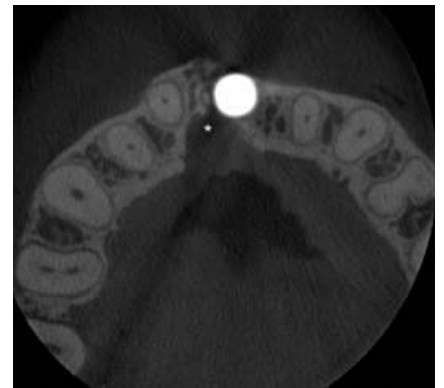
Axial CBCT slice
